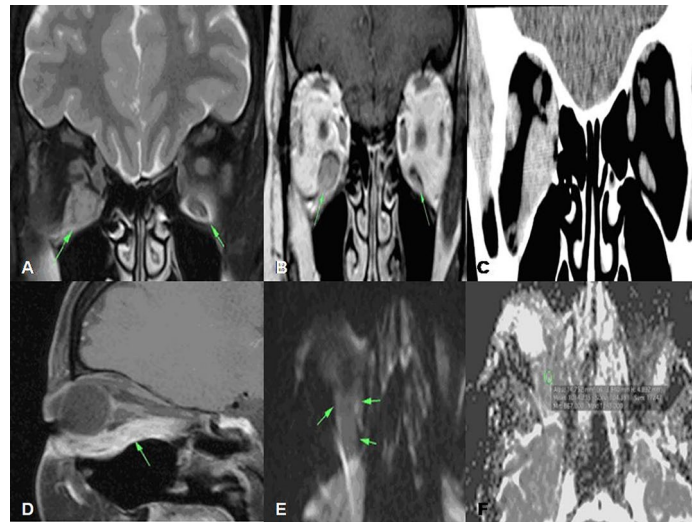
A 34-year-old male patient with acute onset of right-sided dull aching orbital pain and limited orbital movement. Coronal T2WI and T1WI images A, B show enlarged right inferior and lateral recti muscles displaying T1 and T2 isointense signal with minor similar changes involving the left inferior rectus muscle. Complementary non-enhanced CT coronal image C shows bulky right inferior muscle and to lesser extent right lateral rectus muscle. Contrast-enhanced sagittal T1 fat-saturated image D shows marked contrast enhancement of inferior rectus muscle bulk. No diffusion-weighted restriction seen on DWI (b_{500}) (E) and ADC (F). The ADC value is $1.1 \times 10^{-3} \text{ mm}^2/\text{sec}$. Right-sided orbital inflammatory pseudotumor, Myositic type; responded well 2 weeks after therapeutic trial with corticosteroids
